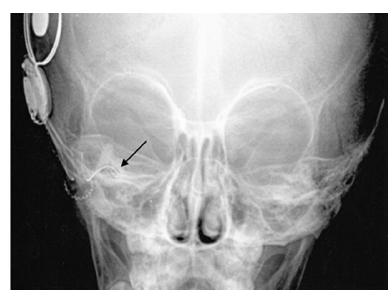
Intraoperative x-ray. Electrode in common cavity.
